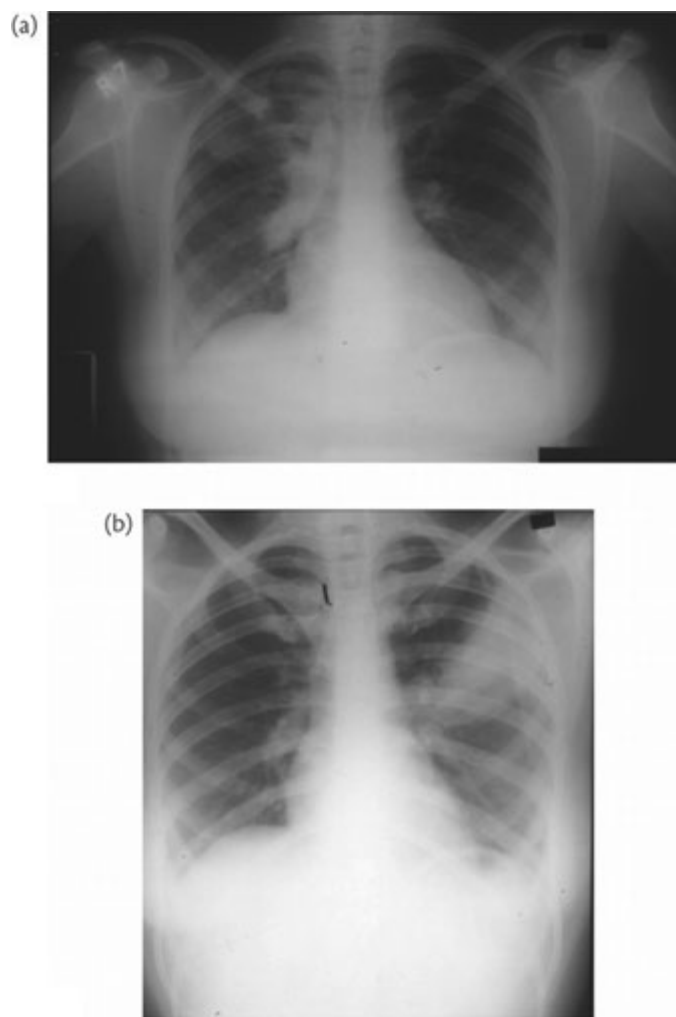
Allergic bronchopulmonary aspergillosis: two radiographs taken 6 months apart from a woman with asthma, peripheral eosinophilia, and high titres of IgE and precipitating IgG antibodies to *Aspergillus fumigatus*.
